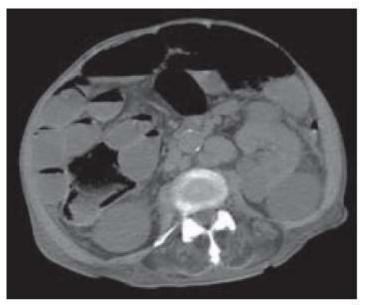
Unenhanced axial CT of the abdomen showing multiple loops of dilated, fluid-filled small bowel in a patient with small bowel obstruction. Both images courtesy of Norwich Radiology Dept.
